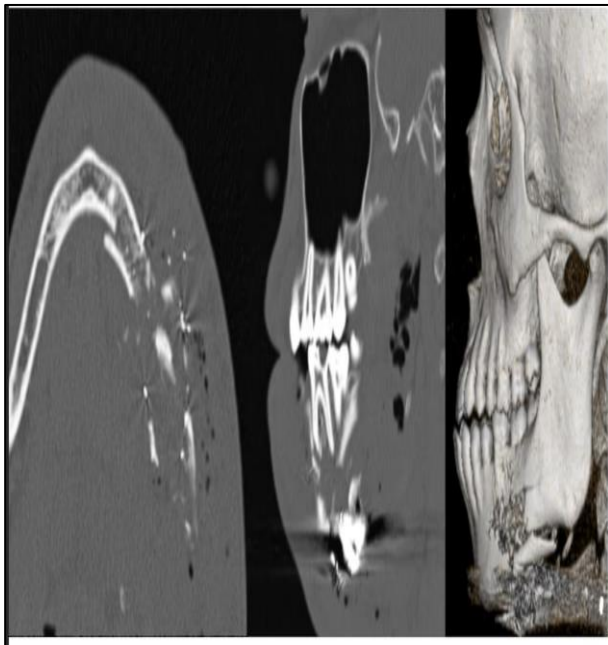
Computed tomography images in axial (left), sagittal (middle) and 3D reconstructive view (right) showing comminuted fracture of body of left mandible with presence of hyper dense particles suggestive of pellet within the GSWI.
